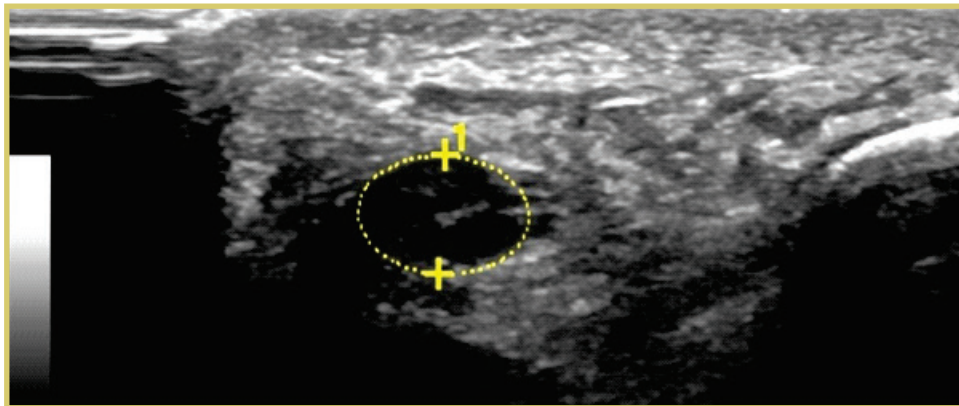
14-18 MHz Sonogram showing hypoechoic nerve with loss of fibrillary echotexture and distorted echogenic rim in transverse view.
